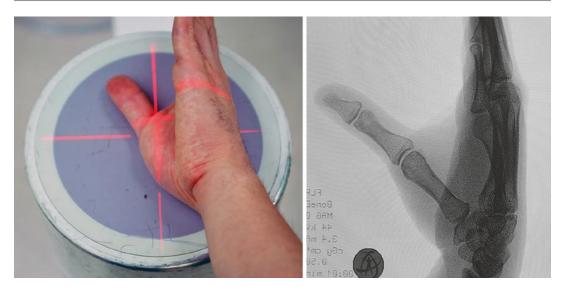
The thumb carpometacarpal joint is best evaluated with a Robert view in which the forearm is fully pronated with the dorsum of the thumb on the cassette and the X-ray beam angled 15° from distal to proximal
